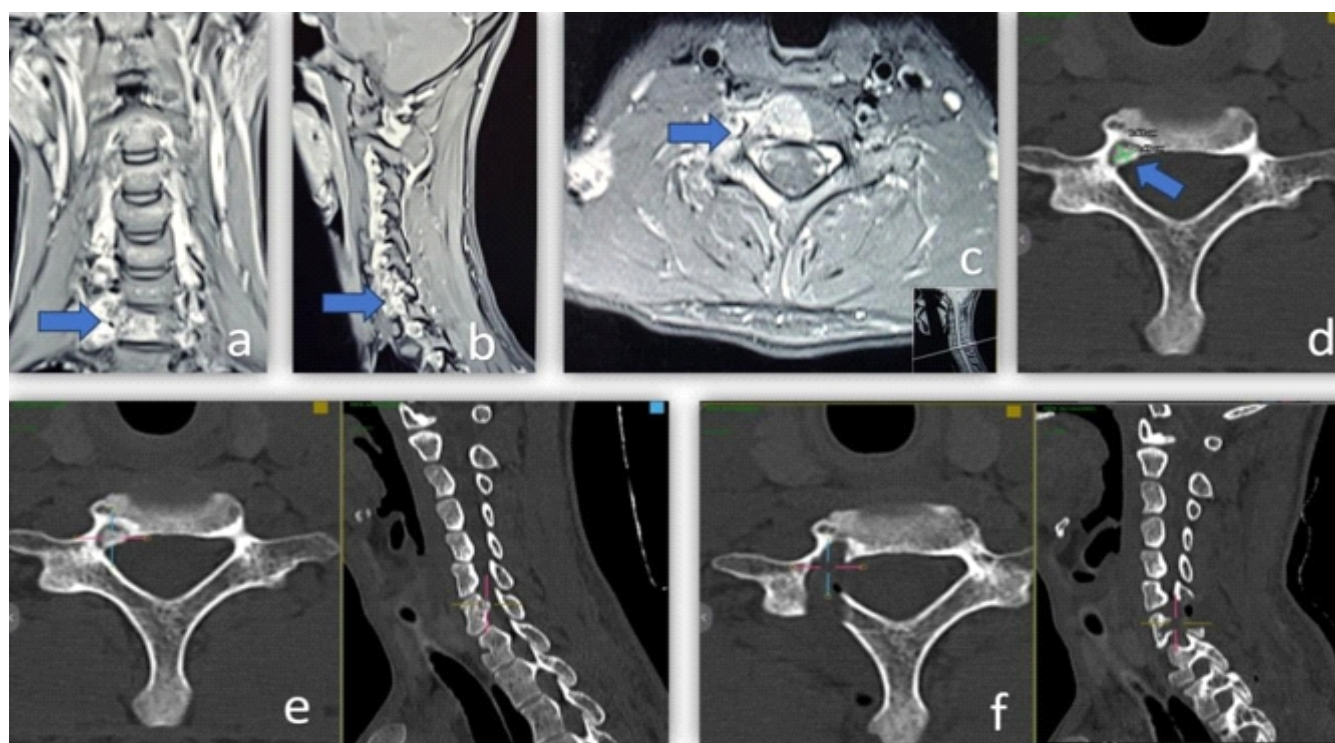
Pre-operative magnetic resonance imaging (MRI), computed tomography (CT), and post-operative CT imaging of right C7 pedicle osteoid osteoma. (a) Coronal MRI showing inflammatory marrow edema and soft-tissue reaction involving the right C7 posterior element (blue arrow). (b) Sagittal MRI demonstrating a focal lesion involving the right C7 pedicle with surrounding inflammatory changes (blue arrow). (c) Axial MRI revealing edema and inflammatory soft-tissue changes adjacent to the right C7 pedicle in close proximity to the vertebral artery (blue arrow). (d) Axial CT image demonstrating a well-defined radiolucent nidus measuring approximately 0.49×0.43 cm with surrounding reactive sclerosis involving the right C7 pedicle (blue arrow). (e) Axial and sagittal pre-operative CT-based images demonstrating precise localization of the nidus within the right C7 pedicle. (f) Axial and sagittal postoperative CT images confirming complete excision of the nidus with preservation of the surrounding cervical osseous anatomy.
